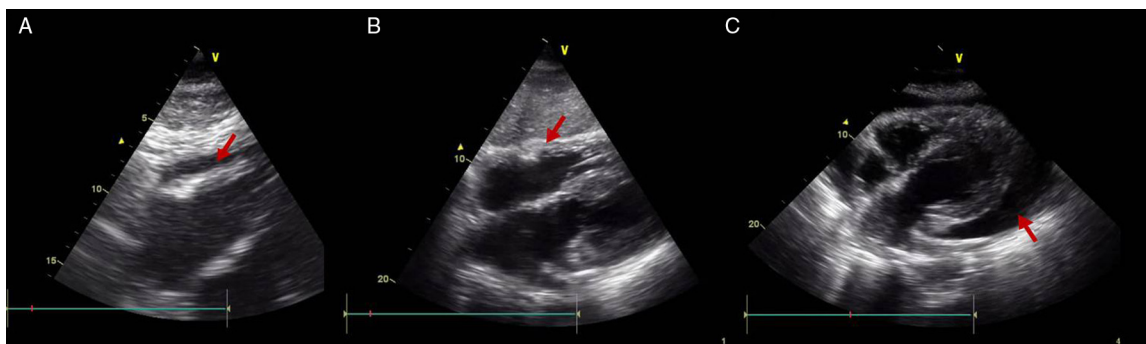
Echocardiographic subcostal views: (A) after permanent pacemaker implantation revealing a new moderate pericardial effusion (arrow); (B) at hospital discharge, after a few days of clinical surveillance with no evidence of pericardial effusion (arrow); and (C) at readmission, with a large pericardial effusion and 'swinging heart' (arrow).
